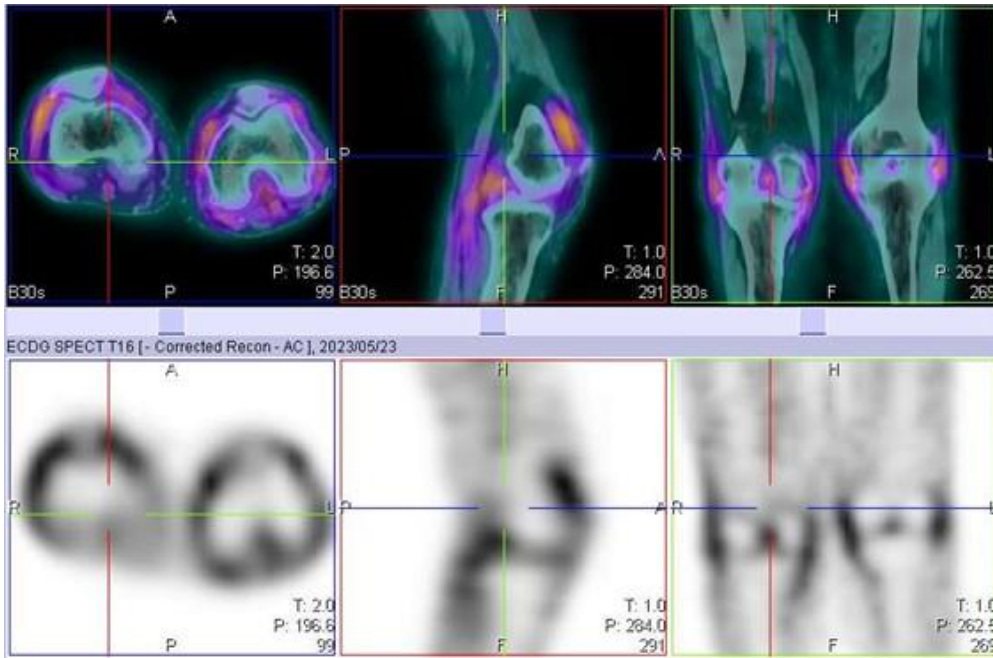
^{99m}Tc -glucosamine SPECT/CT and SPECT images of the knee of a 72-year-old female showing abnormal increased uptake of the radiopharmaceutical in both knees, localised to the synovial space, with no abnormal bone uptake
